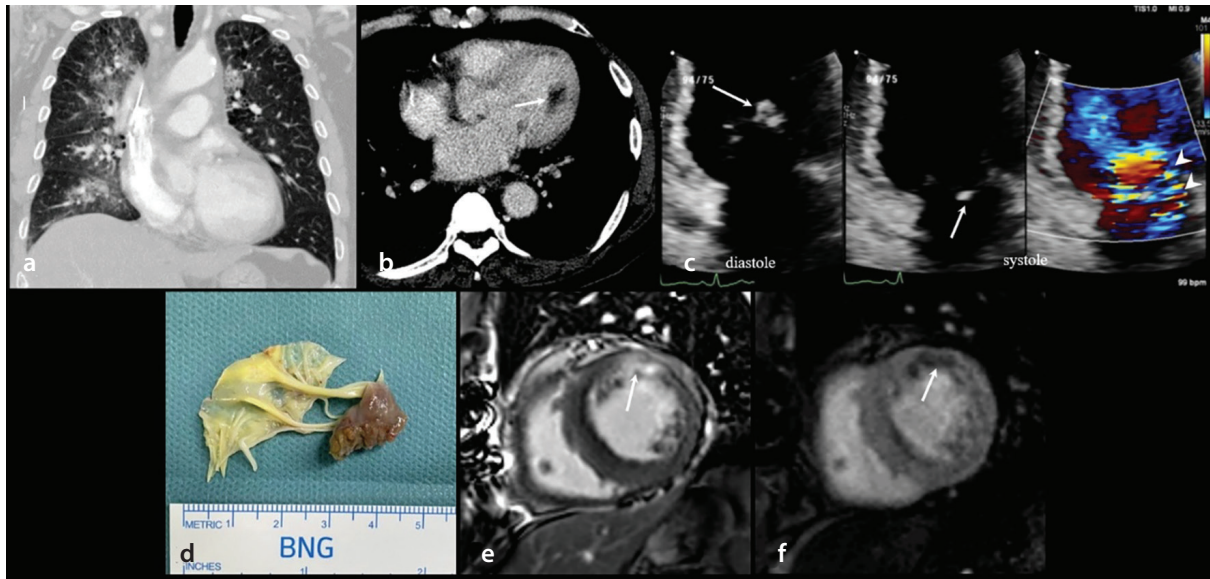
Acute severe MR resulting from papillary muscle rupture in a 68-year-old man who presented with sudden shortness of breath. (a): Coronal MPR image of a chest CT scan shows pulmonary edema in both lungs (primarily in the right lung). (b): Contrast-enhanced axial chest CT image shows hypoenhancement in the anterolateral papillary muscle (arrow). (c): Apical four-chamber view of color Doppler echo images shows severe eccentric MR (arrowheads) resulting from an anterolateral papillary muscle rupture (arrows) and associated mitral valve prolapse (mainly A2). The patient immediately underwent emergency surgery for mechanical mitral valve replacement, and an anterolateral papillary muscle rupture was discovered (d). Two weeks later, the patient underwent stress perfusion CMR imaging to evaluate the underlying cause of the anterolateral papillary muscle rupture. (e, f): LGE (e) and stress perfusion (f) CMR images show transmural delayed enhancement (e, arrow) and stress-induced, patchy transmural perfusion defects (f, arrow) in the mid-anterior and anterolateral LV segments. MR, mitral regurgitation; MPR, multiplanar reformation; CMR, cardiac magnetic resonance; CT, computed tomography; LGE, late gadolinium enhancement.
